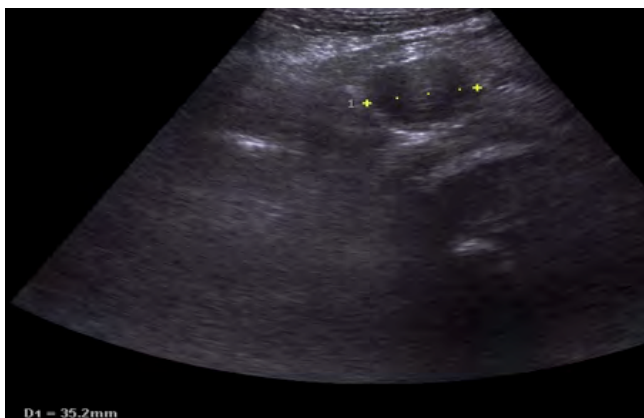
Diameter of abdominal aorta was measured by using portable ultrasound device.
